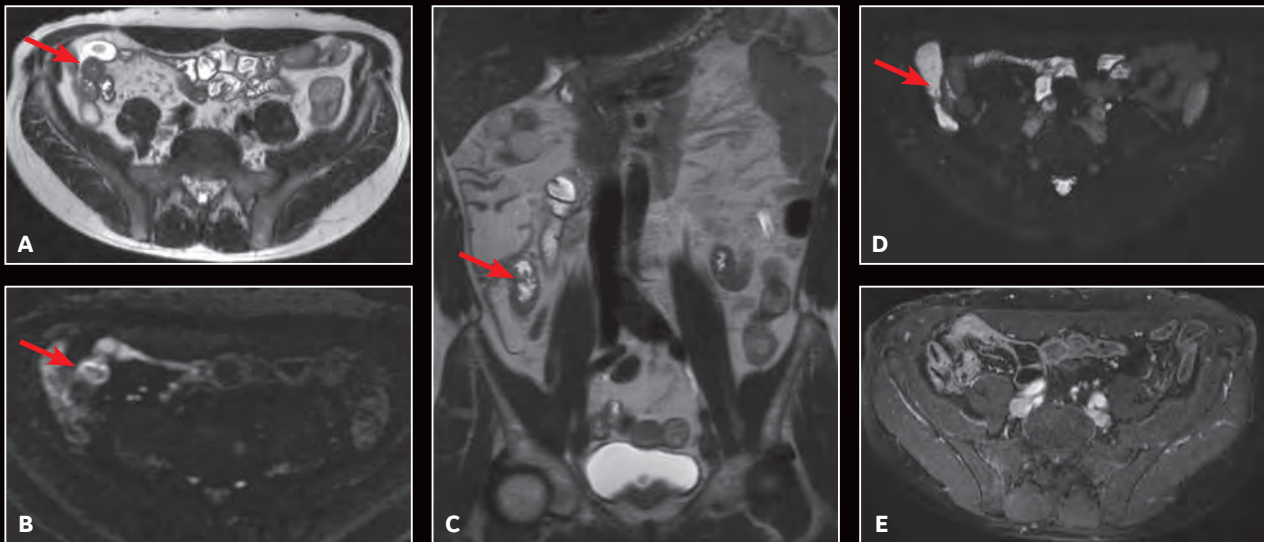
AIR Technology™ AA and PA Coils for abdominal imaging deliver better than expected coverage, signal homogeneity, high spatial resolution and homogeneous fat suppression. A thickening of the terminal ileum (red arrows) is consistent with Crohn's disease. (A) Axial T2 SSFSE; (B) Axial DWI b1000; (C) Coronal T2 SSFSE; (D) Axial T2 SSFSE FatSat; and (E) Axial T1 LAVA ASPIR.
